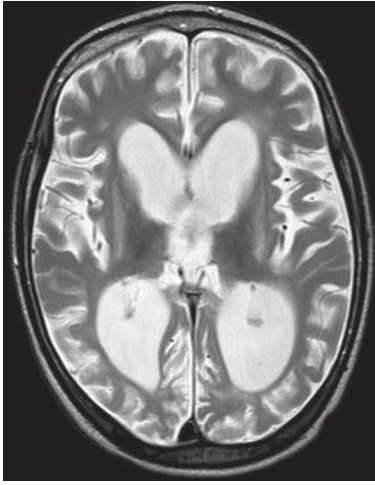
Axial T2-weighted magnetic resonance imaging showing follow-up changes in an infant who suffered a hypoxic injury. Visible reduction of brain volume, despite the widened sulci, thickened skull, large mastoids, and normal head circumference
